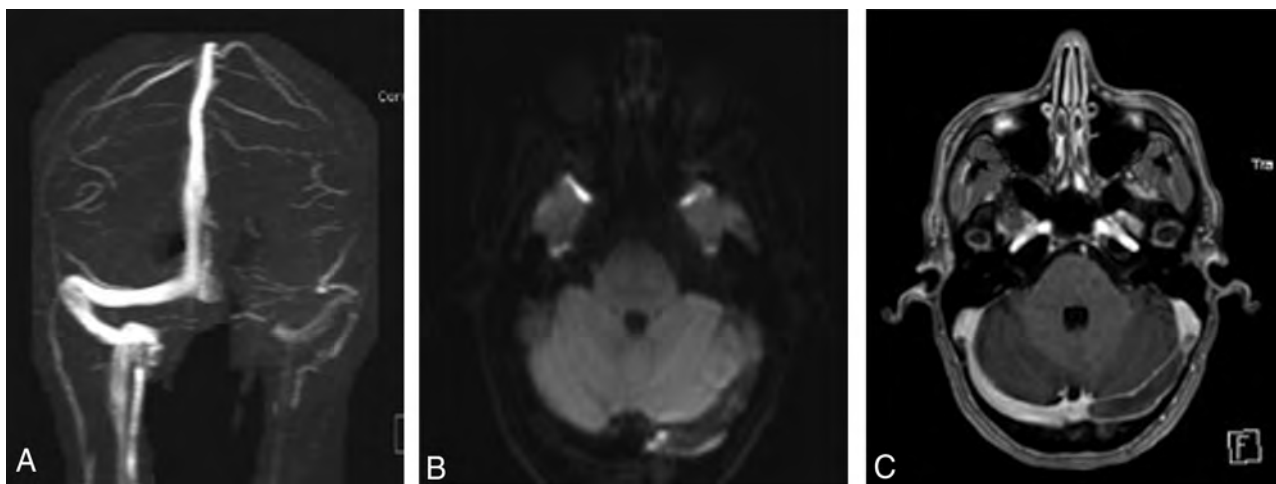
Representative images of a patient demonstrating T2*-hypointense signal with blooming artifacts on DWI. Absence of the left transverse sinus on PC-MRV (A) with associated T2*-hypointense signal with blooming artifacts on DWI (B), corresponding to a filling defect on axial MPRAGE (C).
